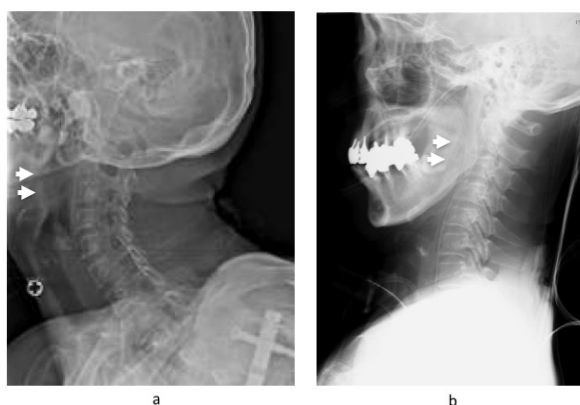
Pre- and postoperative X-ray of cervical spine. (a) Preoperative standing X-ray of cervical spine. Airway is open (arrowhead). (b) Postoperative supine X-ray of cervical spine at airway obstruction. Airway is closed (arrowhead).
